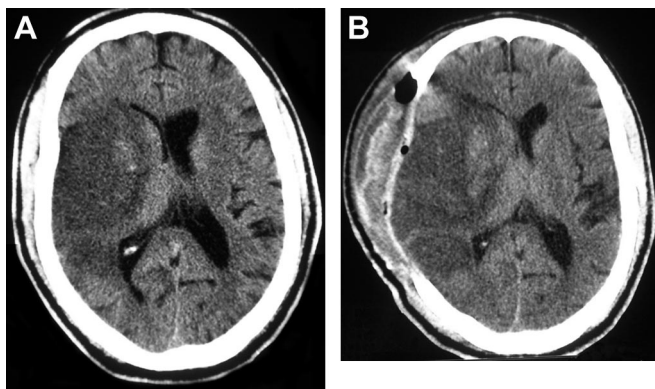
A 58-year-old man presented with acute neurologic deficits related to a large right middle cerebral artery infarction. After 36 hours, he became slightly more lethargic and developed bilateral cerebral ptosis. At that stage, his CT scan (shown in A) showed mass effect from the swollen infarction with early hemorrhagic transformation and shift of midline structures. Hemicraniectomy was promptly performed without complications. Postoperative CT scan (shown in B) demonstrated partial decompression of the mass effect with herniation of infarcted tissue through the skull defect. The patient survived but remained functionally dependent 1 year later.
